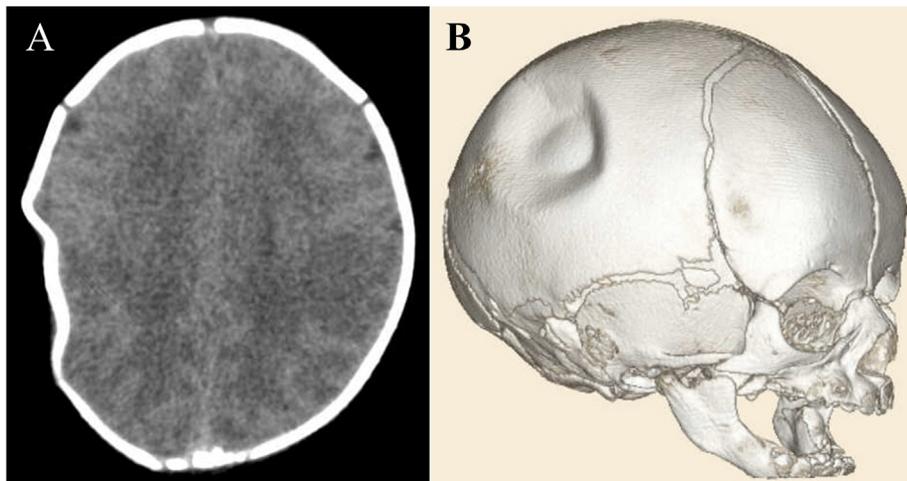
A Axial computed tomography scan demonstrating the depression of the skull with no intracranial hematomas or associated fractures. B Three-dimensional reconstruction images of the computed tomography scan.
